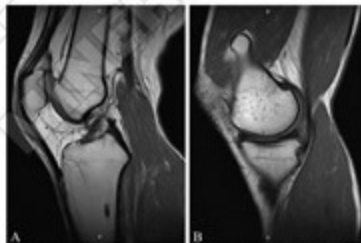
MRI findings. A) T1-weighted image shows expansion and swelling of Hoffa's fat pad, a hypointense small proximal tibial lesion and B) hypointense distal femur exostosis.
